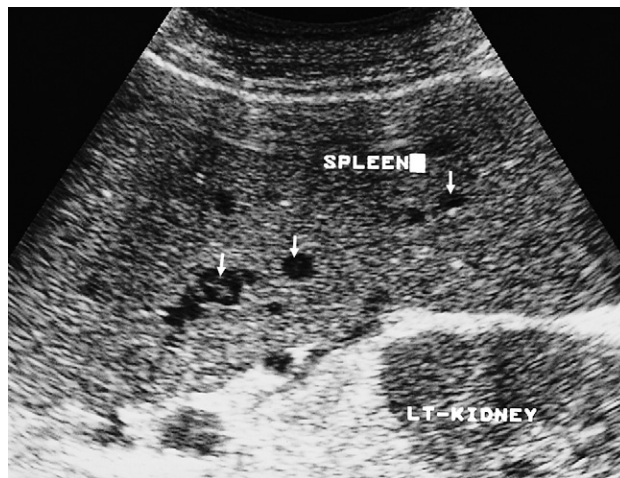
Lymphoma. Ultrasound showing an enlarged spleen with several hypoechoic areas within it; some of these are arrowed.
